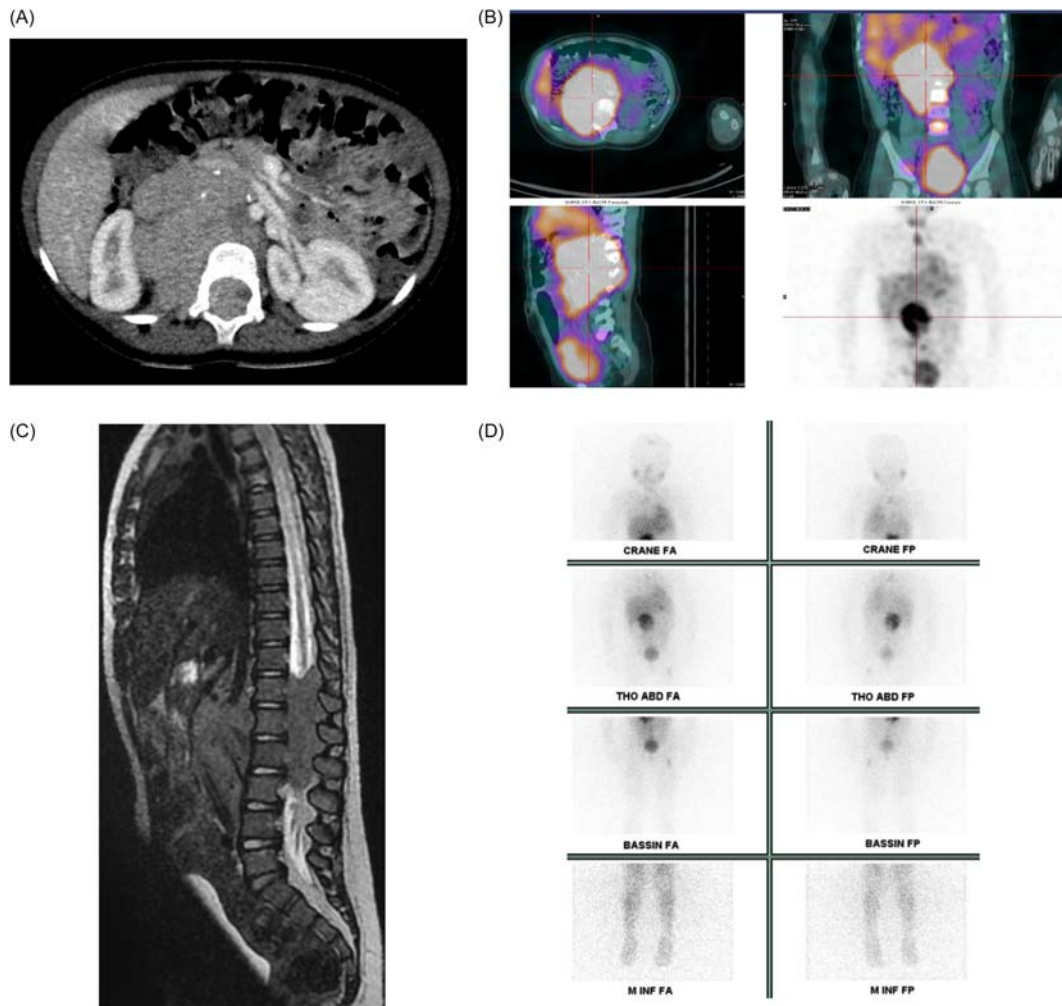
Imaging of a neuroblastoma at diagnosis in a 2-year-old girl. An extensive retroperitoneal latero-aortic mass with microcalcifications shows intraforaminal invasion between D12 and L2 with spinal cord compression. The mass encases the aorta. MRI imaging reveals mediastinal lymph nodes confirmed by MYBG SPECT, which furthermore shows multiple osteomedullary lesions.
